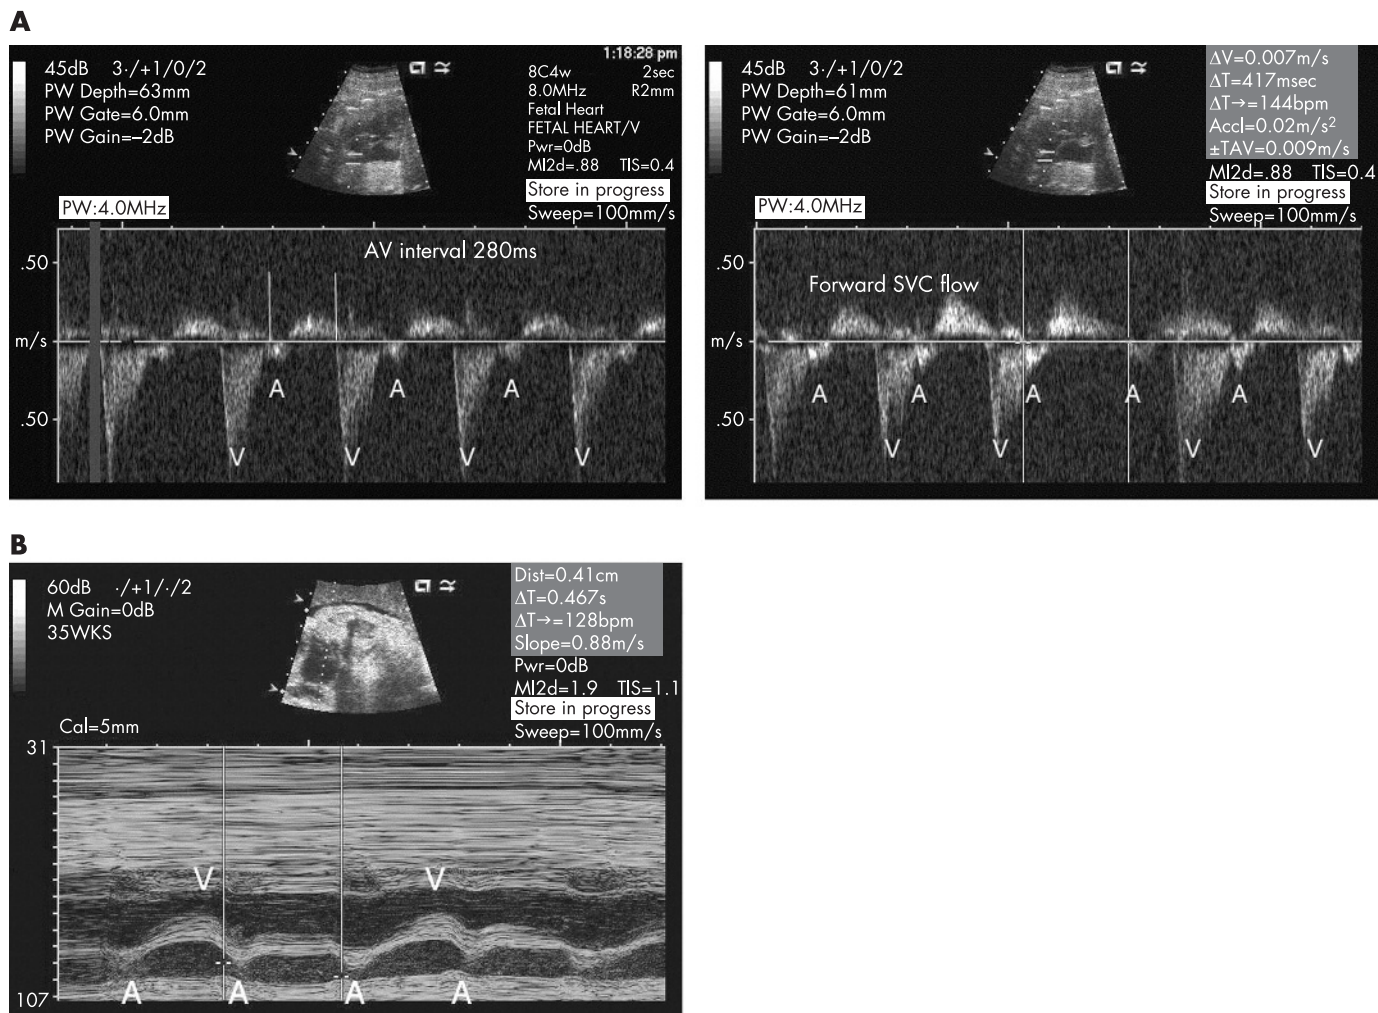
Examples of echocardiographic diagnosis of fetal atrioventricular (AV) block. (A) Simultaneous superior vena cava (SVC)–pulmonary artery (PA) Doppler spectra in a 32 week gestational age fetus with double-inlet ventricle associated with L-ventricular looping, transposition of the great arteries and pulmonary stenosis. A prolonged A–V interval of 280 ms (normal <130 ms) suggested the presence of first degree AV block which was present throughout the examination. Within 3 weeks there was progression to intermittent second degree (image on right), and by term there was complete AV block necessitating early pacemaker therapy. A: retrograde SVC flow in atrial systole; V: forward flow in the PA during ventricular systole. (B) This M mode tracing demonstrates the findings in a 30 week fetus with isolated AV block due to maternal autoantibodies. There is lack of AV synchrony with an atrial rate of 128 bpm and ventricular rate of 60 bpm. A: atrial systole; V, ventricular systole.
